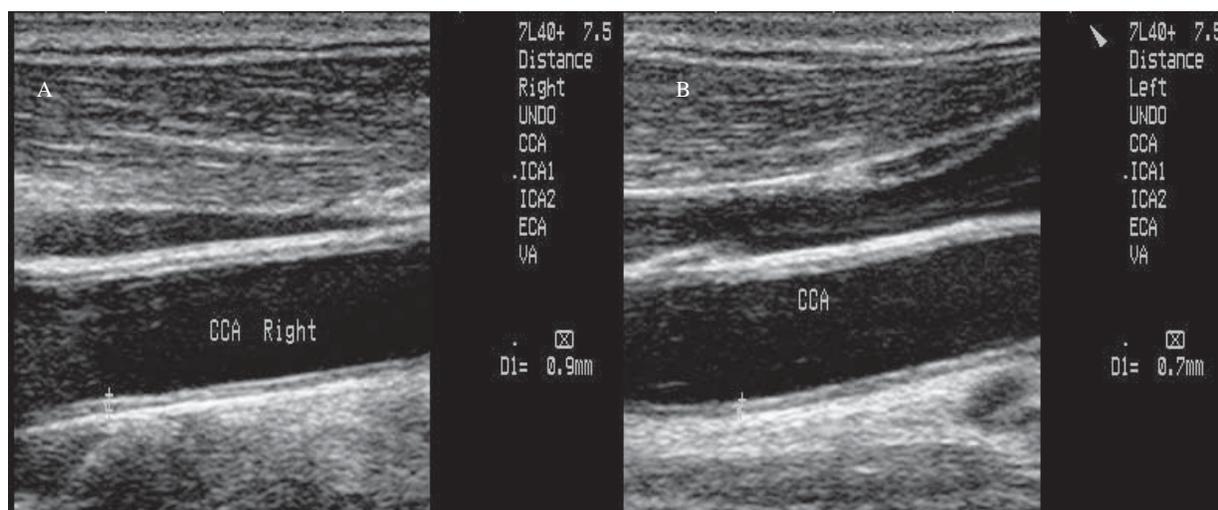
High resolution grey-mode ultrasonography showing intimo-medial complex thickness measurement in (A) right and (B) left CCA. Abbreviation, CCA= common carotid artery.
